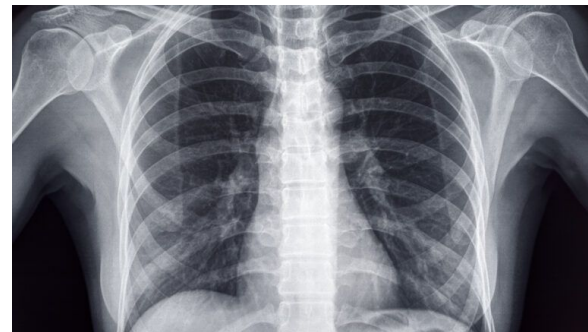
Medical X-ray image in an AI dataset.
